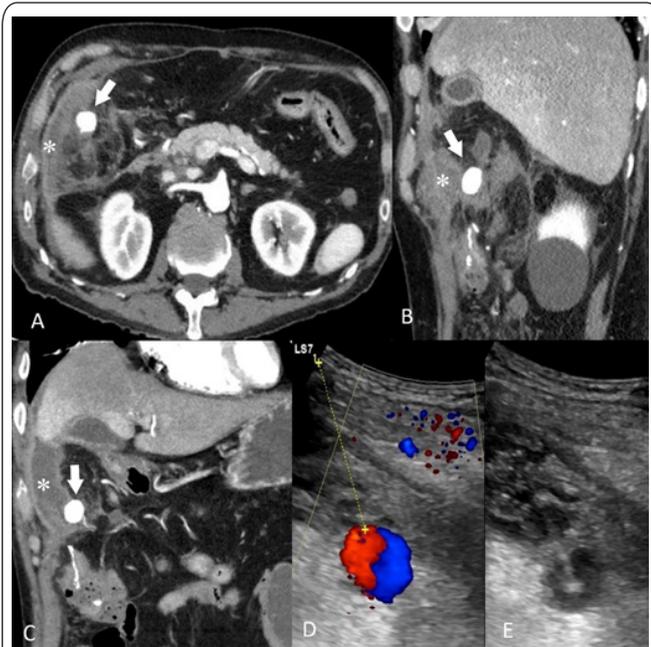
CT angiogram of the abdomen [A (axial), B (sagittal), and C (coronal)] demonstrates a superficial intra-abdominal pseudoaneurysm (arrows) which measures 16 x 16 x 15 mm with an indefinable neck arising from a terminal middle colic artery. No collateral blood supply was identified. The pseudoaneurysm is located in the vicinity of the intra-abdominal collections (asterisks) which had occurred as a complication of the laparotomy and reversal of end-ileostomy procedure. With the patient in the lateral decubitus position, UGTI with 800 International Units (IU) was performed until successful cessation of luminal flow was noted (Ultrasound images D and E). The pseudoaneurysm remains thrombosed on follow-up imaging.
